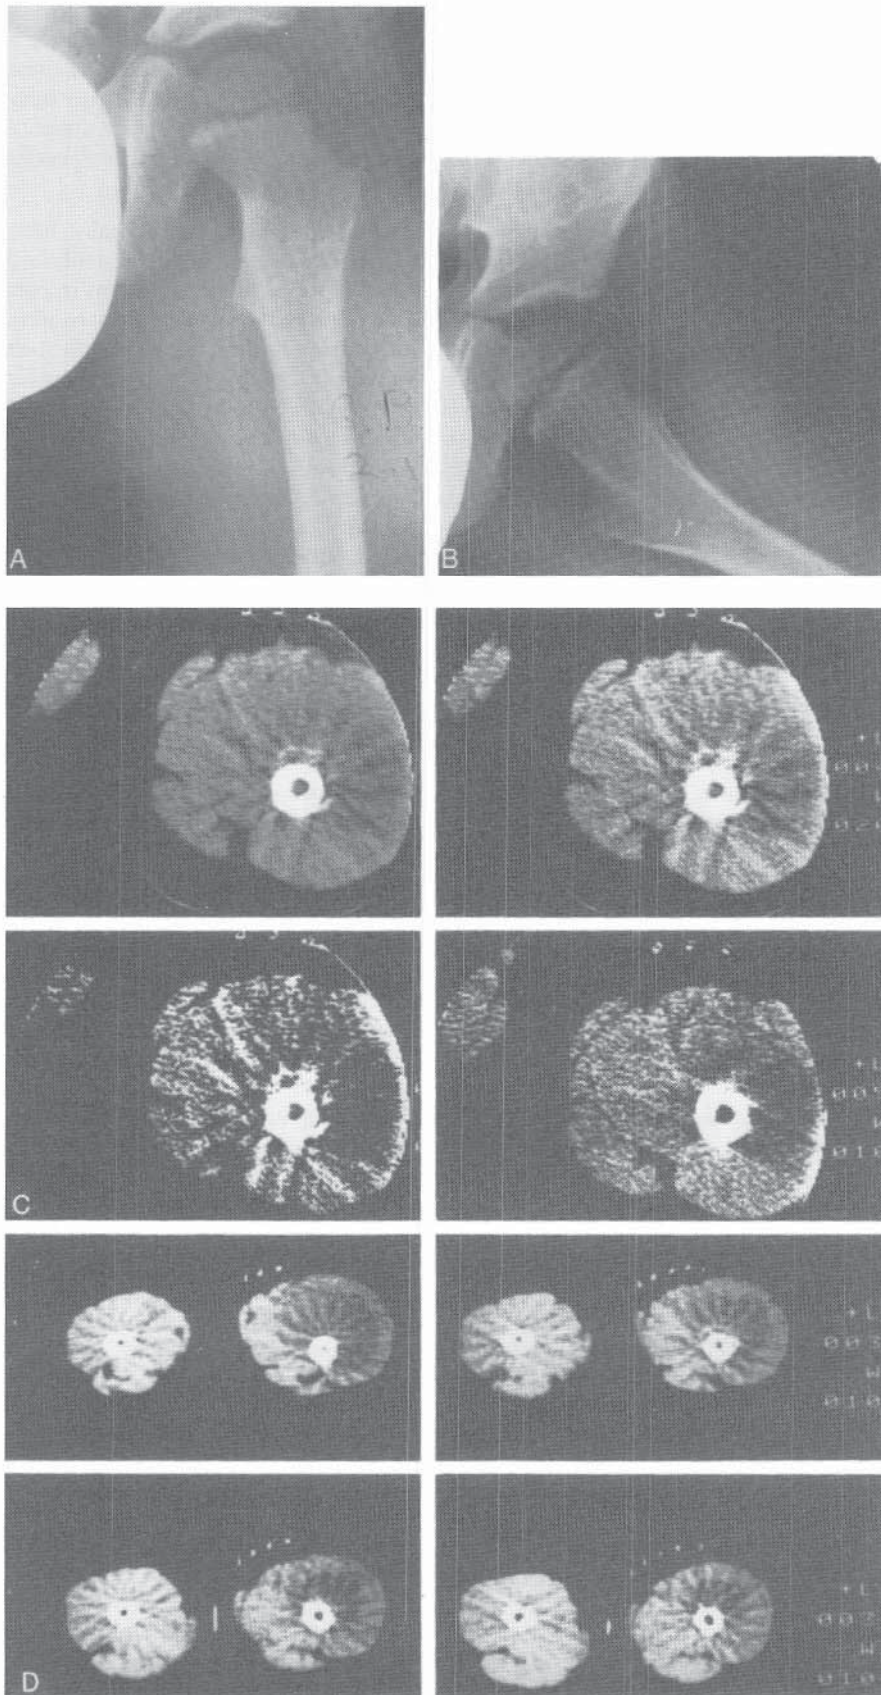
Ewing's sarcoma of the proximal femur in a 5-year-old boy. A and B, AP and lateral radiographs of the proximal femur showing subperiosteal reaction and mottling of the outer cortex. C and D, CT scan showing cross sections of the bony and soft tissue changes in the proximal femur. Treatment was by irradiation and chemotherapy.
